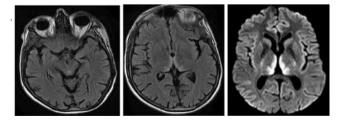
Cerebral MRI showing bithalamic and peri aqueducal hypersignal in FLAIR sequences (A and B) which persist in Diffusion sequences with an elevated ADC (C).
